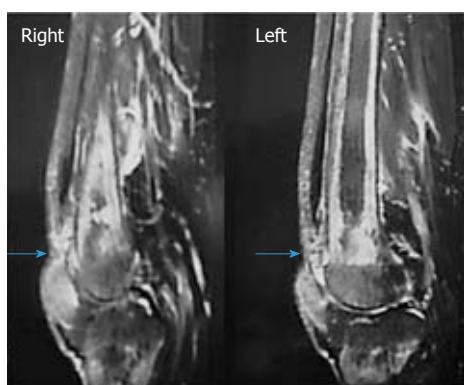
Magnetic resonance imaging of the knee (sagittal view) showing a complete bilateral rupture of the tendon.
